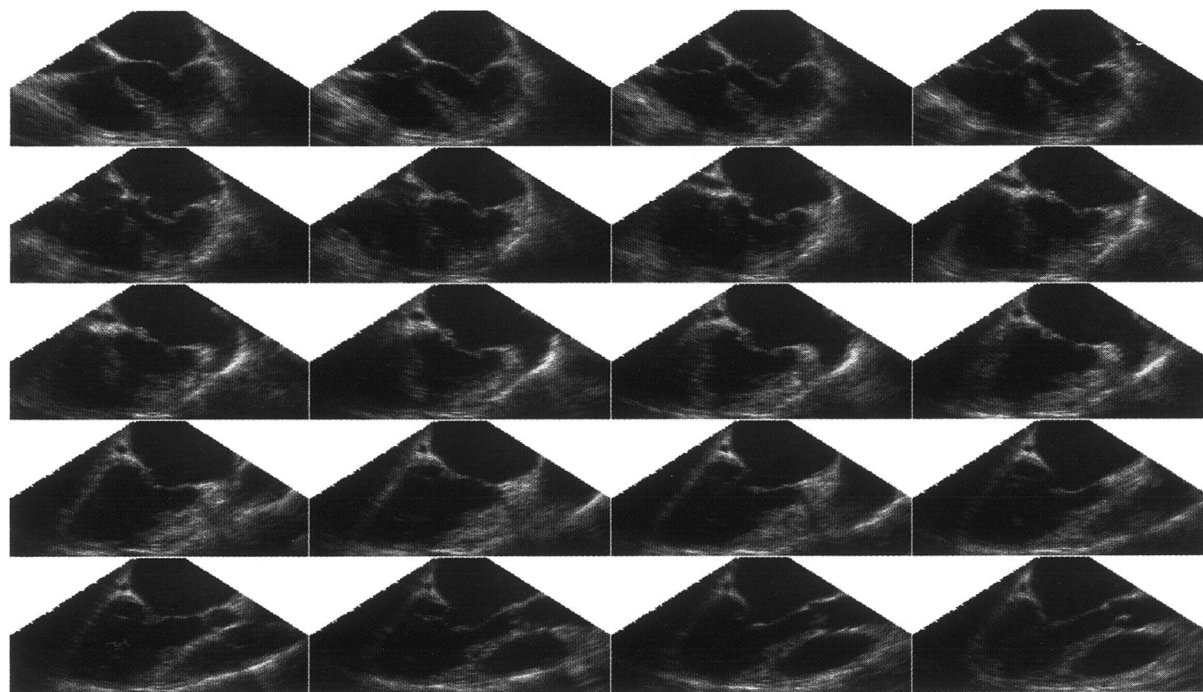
Multiplane transesophageal echocardiography acquired in the rotational approach. From left to right and top to down, it shows the sequence of acquisition from 0 to 80° and with 4° for each frame.
